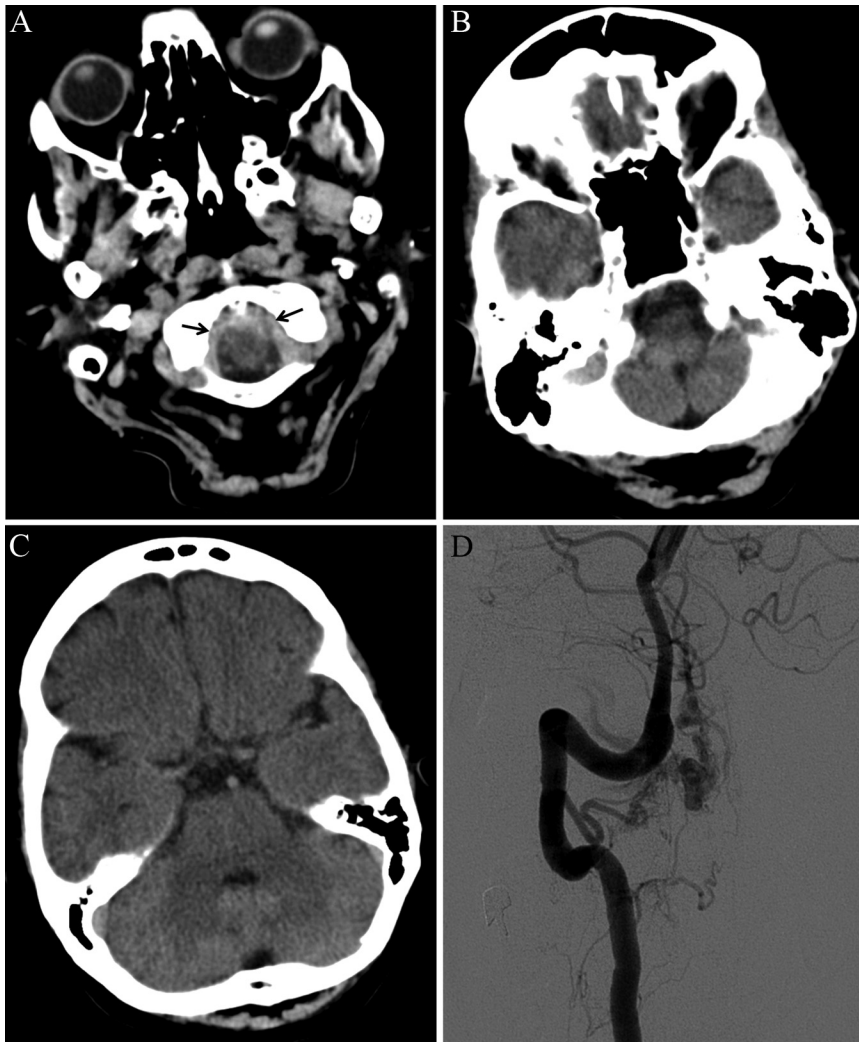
Head computed tomography (CT) and conventional angiography of patient with cervical arteriovenous malformation. Imaging results in a patient who presented with acute neck pain, nausea, and neck stiffness. Head CT (panels A–C) showed hyperdensity at the level of the foramen magnum (arrows), but was determined inconclusive. Conventional angiogram (panel D) showed the presence of a cervical arteriovenous malformation.
